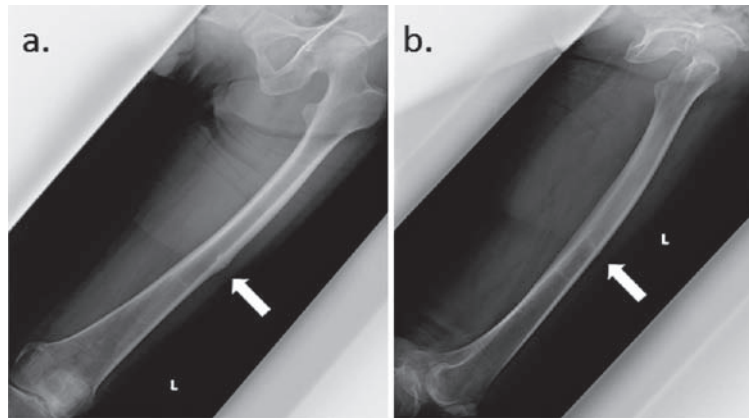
Plain radiograph showing cortical thickness with radiolucent line (white arrow)
